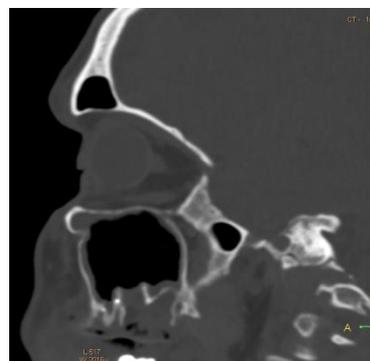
CBCT fragment one month after surgical treatment. There are signs of decreased intensity of the MS shadowing areas
